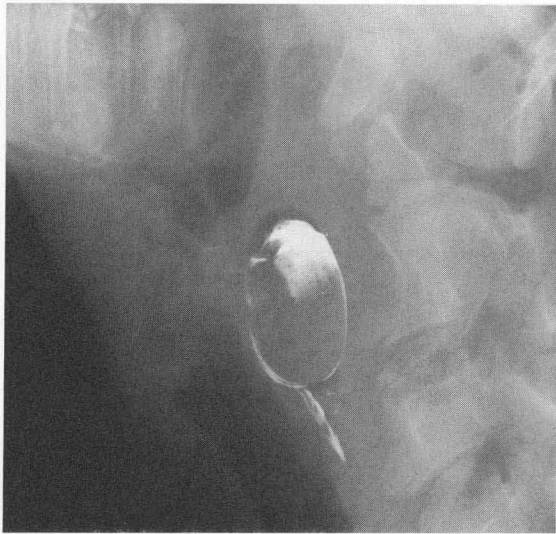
Lateral radiographic view after administration of barium paste. The oval mass is seen to be located in the cranial portion of the esophagus. Less soft tissue opacity overlying the larynx is evident in this radiograph, although laryngeal anatomic features remain unclear.
